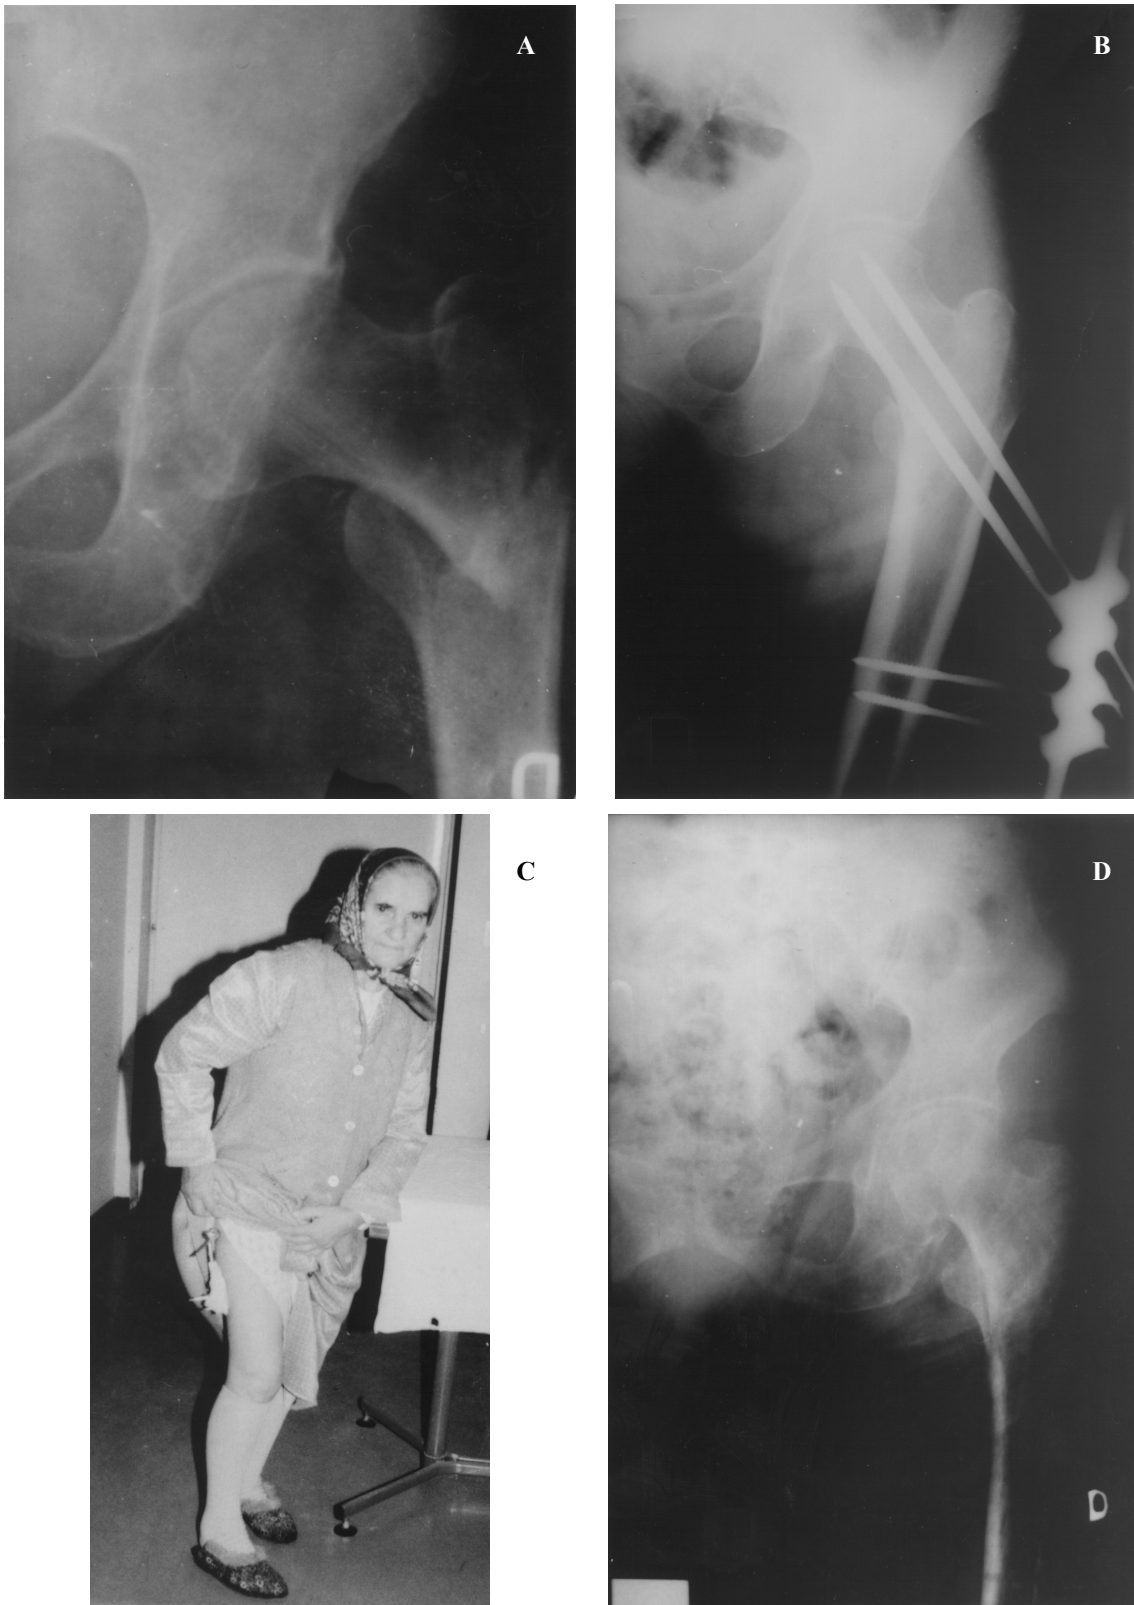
2a. x-ray of pertrochanteric fracture before the fixation
